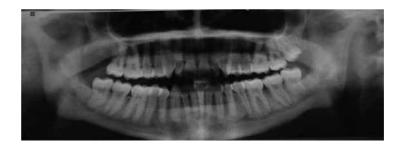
A panoramic radiograph of a 27-year-old patient with chronic pain of the head and neck muscles. The radiograph is showing signs of chronic condylar overload presented in the form of bilateral degenerative changes.
